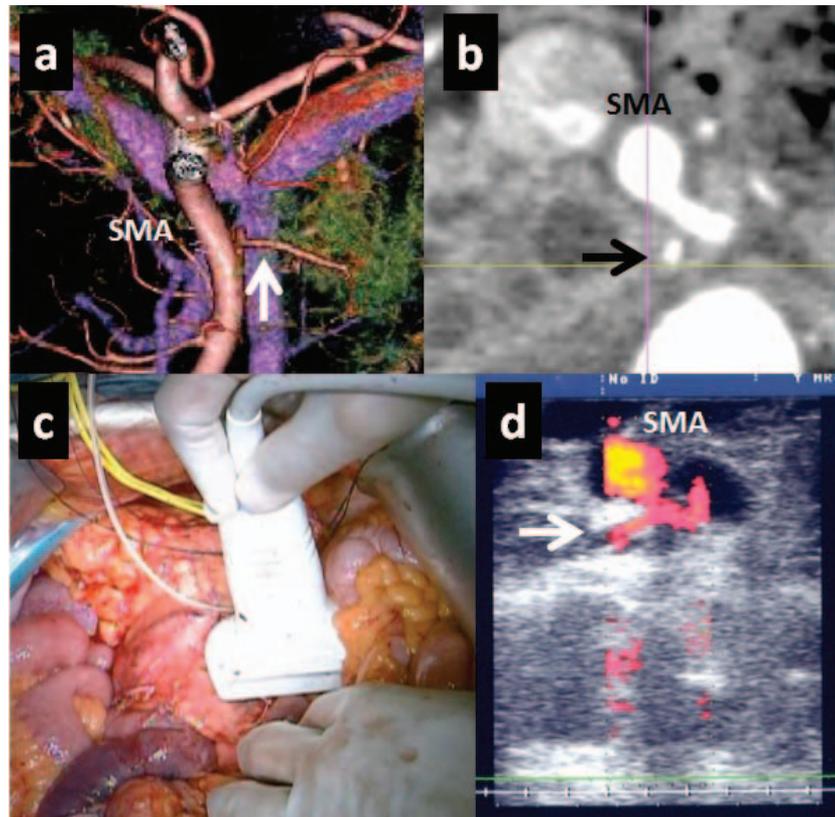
Intraoperative Doppler ultrasonography. (a) A rear view of a volume-rendered image showing arteries (red), the portal system (purple), the pancreatic parenchyma (green), and the inferior pancreaticoduodenal artery (IPDA; black arrow). (b) Multiplanar reconstruction image of the bifurcation of IPDA (black arrow). (c) Intraoperative examination around the pancreas head. (d) Doppler ultrasonogram of the IPDA diverging from superior mesenteric artery (SMA) using power Doppler mode (white arrow).
